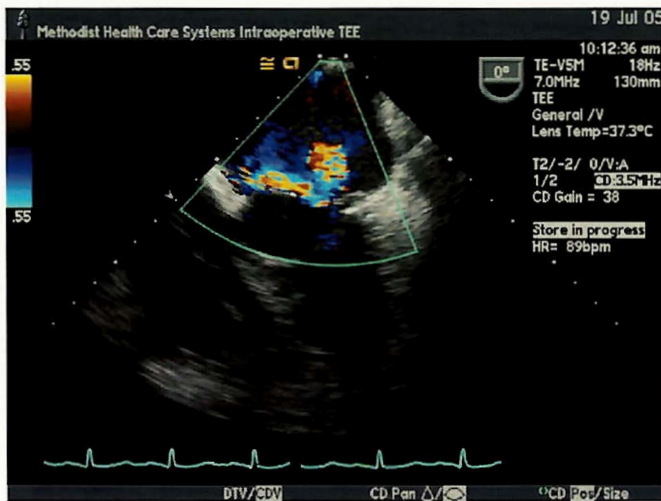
Midesophageal four-chamber view on same patient with color flow Doppler during systole revealing significant mitral regurgitation
